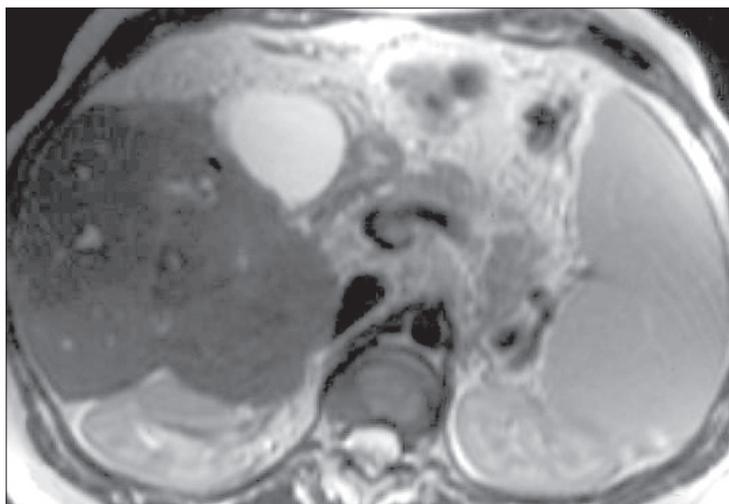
Spherical shape of the liver. Transverse T2-weighted MR image shows lobulation in liver contours and a spherical liver shape. This shape was observed in the cases where left lobe atrophy and caudate lobe hypertrophy were evident.
